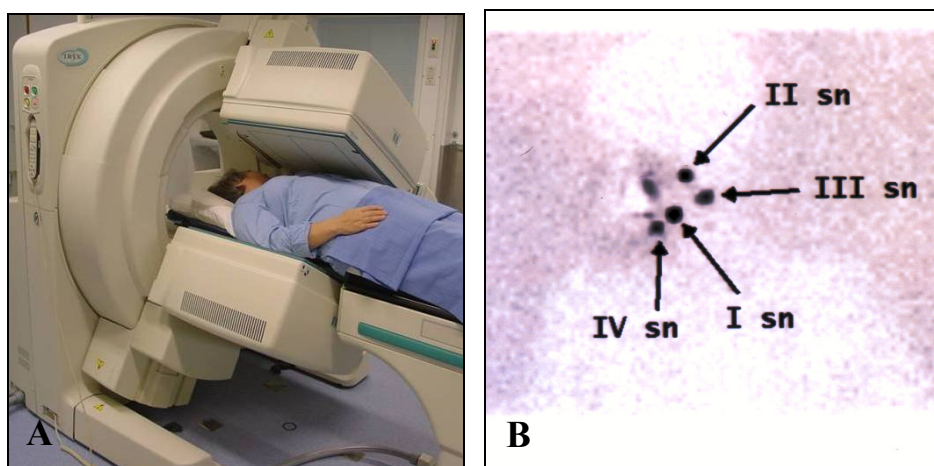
A. Preoperative scintigraphy with a gamma camera. B. A lymphoscintigraphy of a patient with a melanoma in the left cheek indicates the locations of four sentinel nodes (sn). Sn II was located and later excised in the parotid gland.
